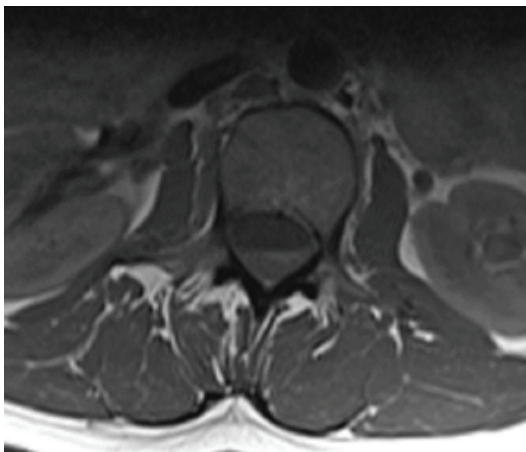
Axial T1-weighted LS MRI scan shows acute spinal subdural hematoma at the level of L2 vertebral body.
